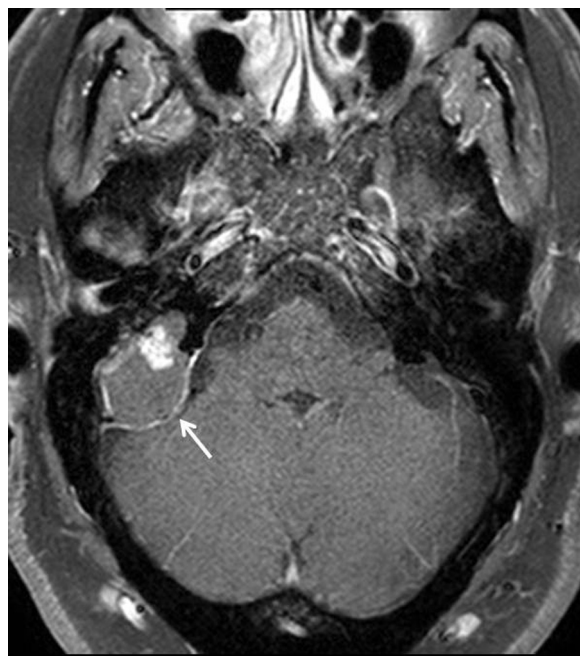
Axial T1-weighted magnetic resonance imaging scan with no contrast, showing a well-demarcated isointense lesion (to dura) (arrow) in the right cerebellopontine enclosing distinct hyperintense foci.
